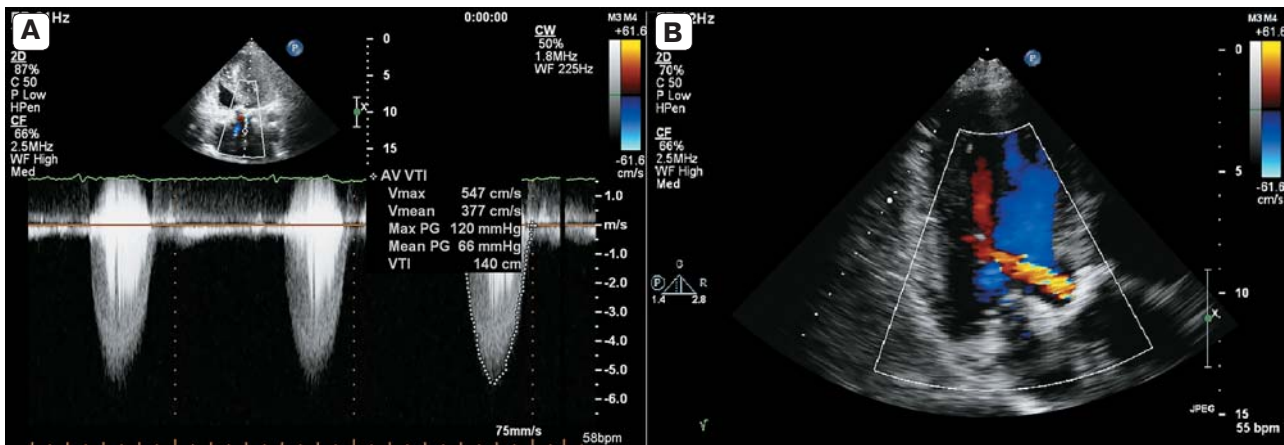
Preoperative transthoracic EchoCG. A – Data of the continuous wave Doppler. B – Color-guided Doppler assessment of the AV – grade 2 aortic regurgitation.
